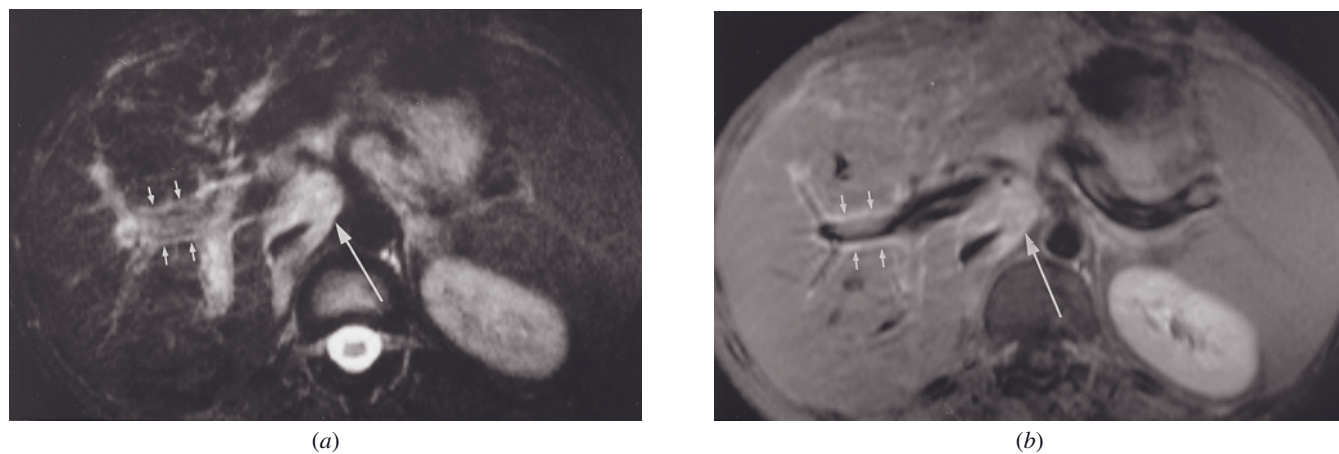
Viral hepatitis. T2-weighted fat-suppressed SE (a) and 90-s fat-suppressed postgadolinium SE (b) images in a patient with HIV infection and positive serology for hepatitis B and C. On the fat-suppressed T2-weighted sequence (a), porta hepatis and para-aortic lymph nodes (long arrow, a) are clearly shown as high-signal-intensity masses in lower-signal-intensity background. High signal within the liver in a periportal distribution is also present (small arrows, a). This periportal abnormality identified on the T2-weighted image is shown to be enhancing tissue (small arrows, b) on the gadolinium-enhanced T1-weighted fat-suppressed image (b). Gadolinium enhancement distinguishes periportal inflammatory or neoplastic tissue from edema, the latter would appear signal void after contrast. Enhancement of adenopathy (long arrow, b) is also appreciated.
